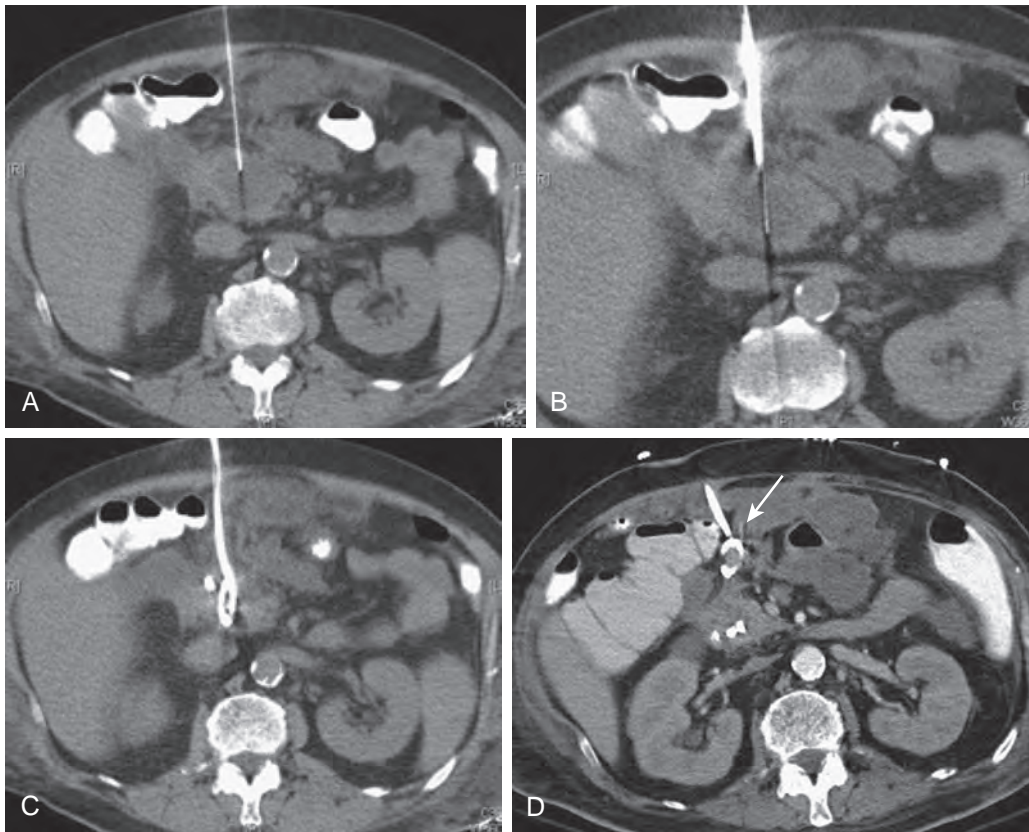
Percutaneous drainage catheter dislodgment. A. Axial noncontrast CT image shows needle sampling (22 gauge) of pancreatic necrotic collection through an anterior approach. B. Axial noncontrast CT image shows percutaneous drainage catheter (14F) insertion by a tandem technique. C. Axial noncontrast CT image shows percutaneous drainage catheter in place and complete resolution of pancreatic fluid collection. D. Axial contrast-enhanced CT image obtained 14 days after the drainage procedure shows dislodgment of the catheter (arrow) and spillage of pancreatic fluid in the omentum and peripancreatic tissues.
